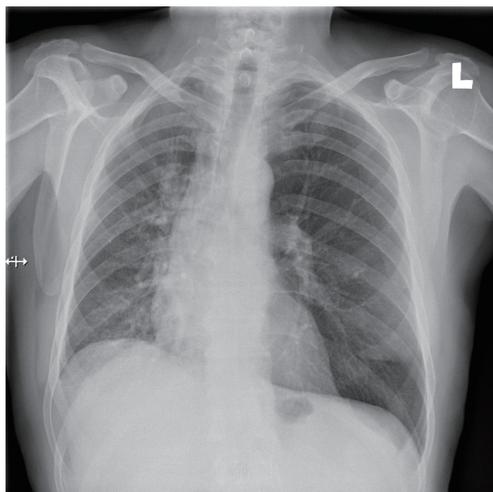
Chest X-ray, posterior-anterior view – persistent peribronchial thickening in the lower lobes.
